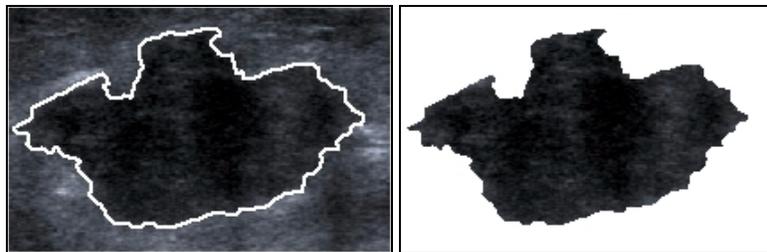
Example of segmented ultrasound breast image
